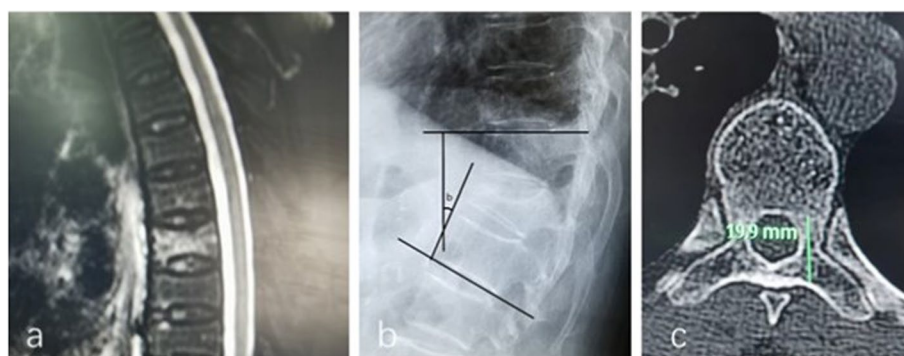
a The MRI reveals a mild wedge deformation of the vertebral body, along with diffuse high signal intensity, indicating a T7 vertebral body fracture in a representative patient. b Cobb angle was utilized to evaluate the kyphosis angle of thoracic vertebrae. c The distance from the entry point of the pedicle to the posterior edge of the vertebral body was preoperatively measured via CT
